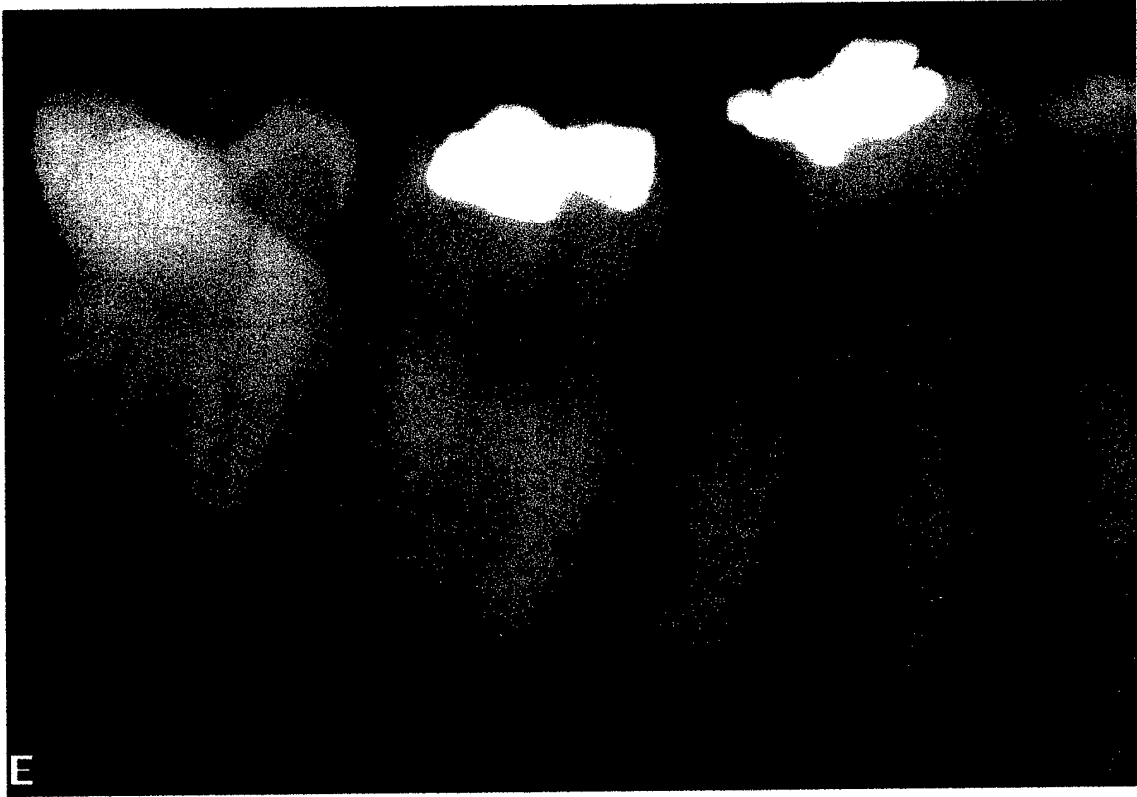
Test image with no periapical radiolucency associated with root identified by digital marker.
